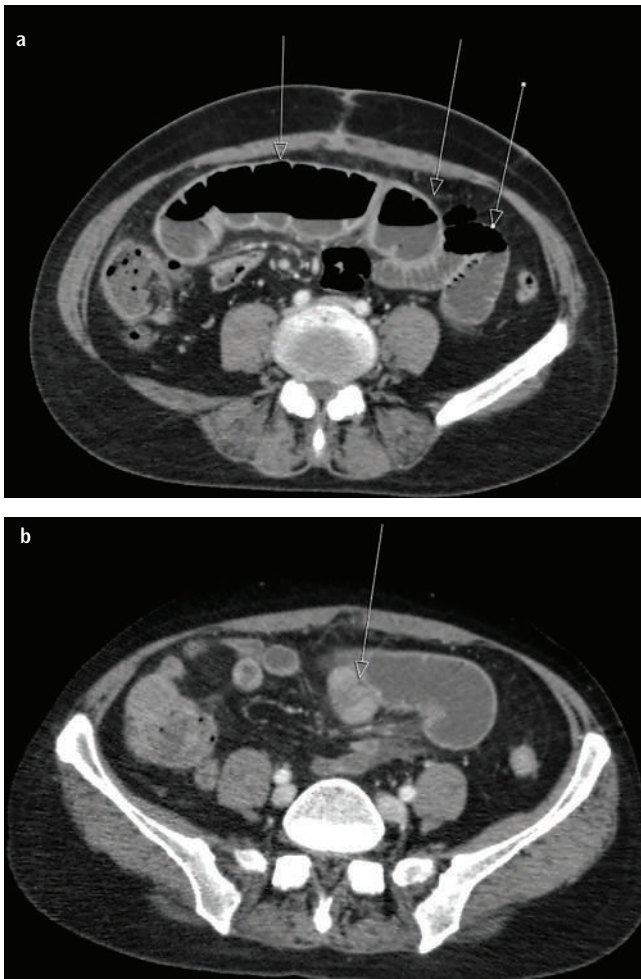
Ileus finding on contrast-enhanced abdominal CT scan. a) Findings of proximal ileus. b) Asymmetric wall thickness increase in ileal loops.
